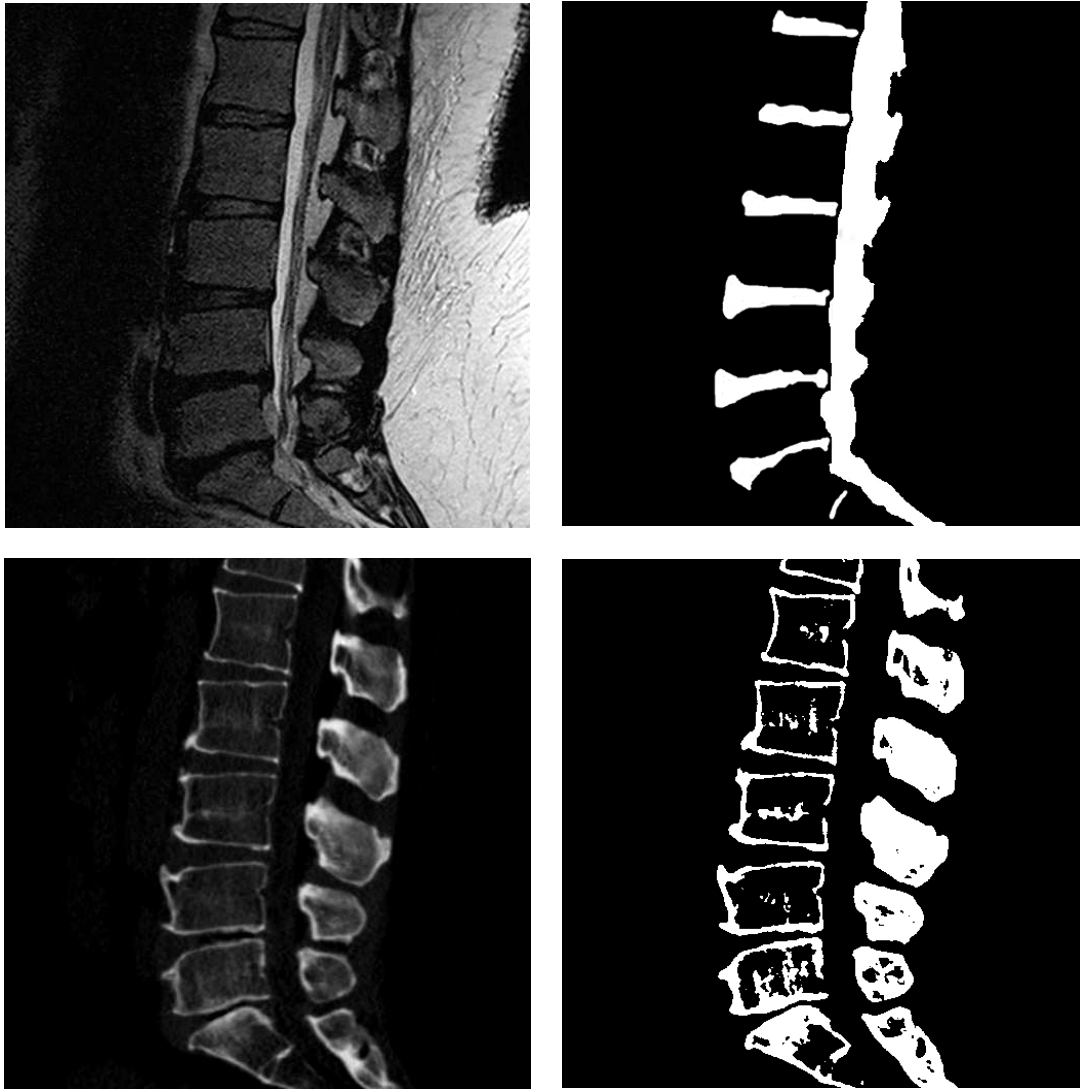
Sample masks for validating the quality of the fusion algorithm. Top left: sample MR image, Top right: soft tissue Mask, Bottom Left: sample CT image, Bottom right: bone detail mask
